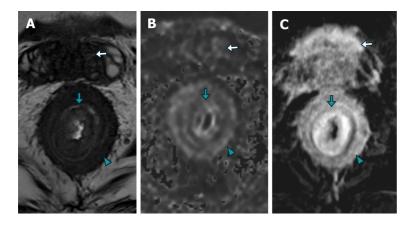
Axial magnetic resonance imaging of case 2. A-C: The imaging findings reveal a stratified parietal thickening of the rectal wall, characterized by concentric areas of intermediate signal intensity on T2-weighted imaging (A), restricted diffusion on diffusion-weighted imaging (B), and contrast enhancement on post-contrast T1-weighted volumetric interpolated breath-hold examination imaging with subtraction (C), affecting both the submucosal (green arrow) and muscular/subserosal planes (arrowhead) resembling a "linitis plastica" appearance. In addition, there is neoplastic involvement of the base of the seminal vesicles (white arrow).
